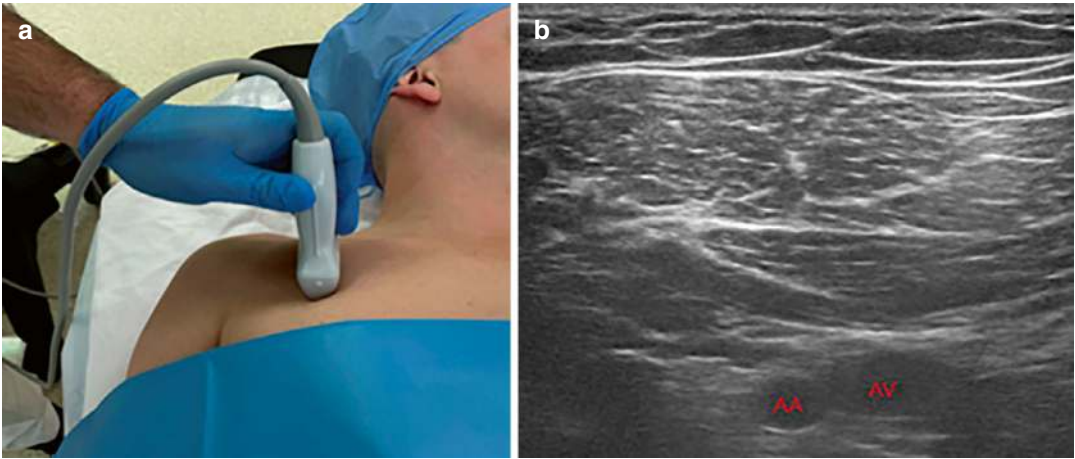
A two-panel image. Panel (a) shows a medical professional using an ultrasound device on a patient's shoulder, with the patient lying down and covered with a blue drape. Panel (b) is an ultrasound image displaying
